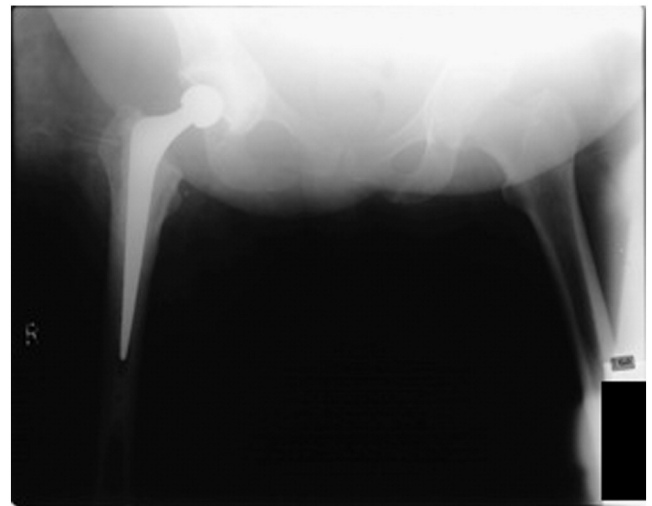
Immediate post-operative radiograph of cavitary defect demonstrating good socket positioning.
